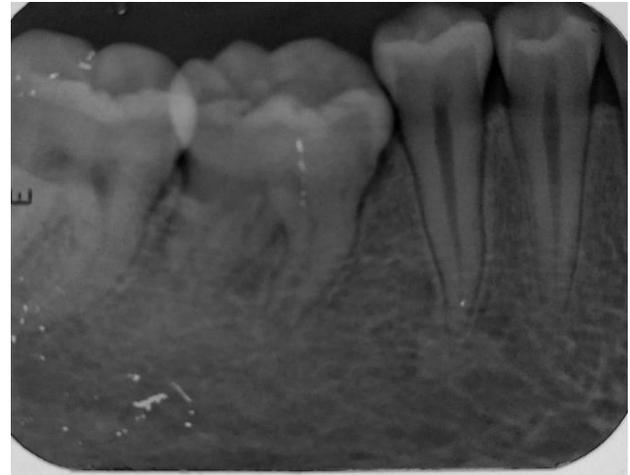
Radiographic follow-up one year after the surgery.
